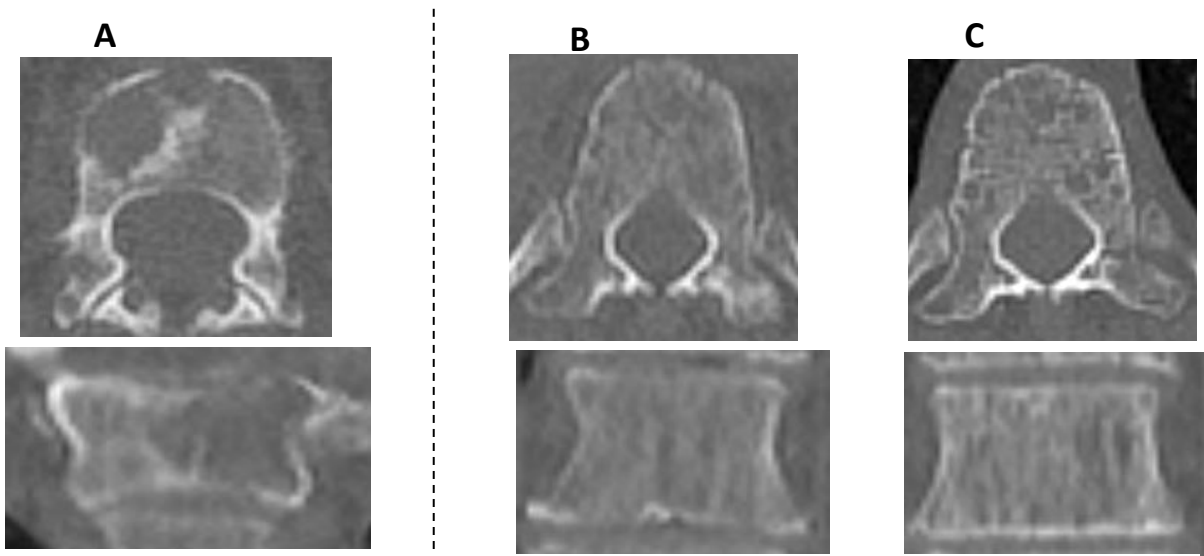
CT images of (A) BRATS006 baseline CT of selected vertebra highlighting the large lytic lesion (B) Baseline CT of BRATS011 showing no visible lesions (C) Follow-up CT of BRATS011 showing small lesions.
